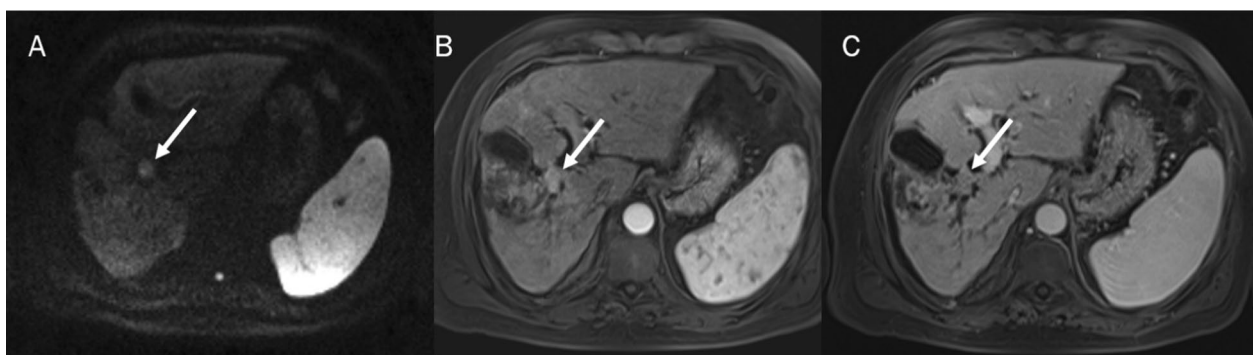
In DWI (A: b 800 s/mm²) the lesion shows restricted signal and arterial hyperenhancement (B) with progressive enhancement (C) during contrast study
